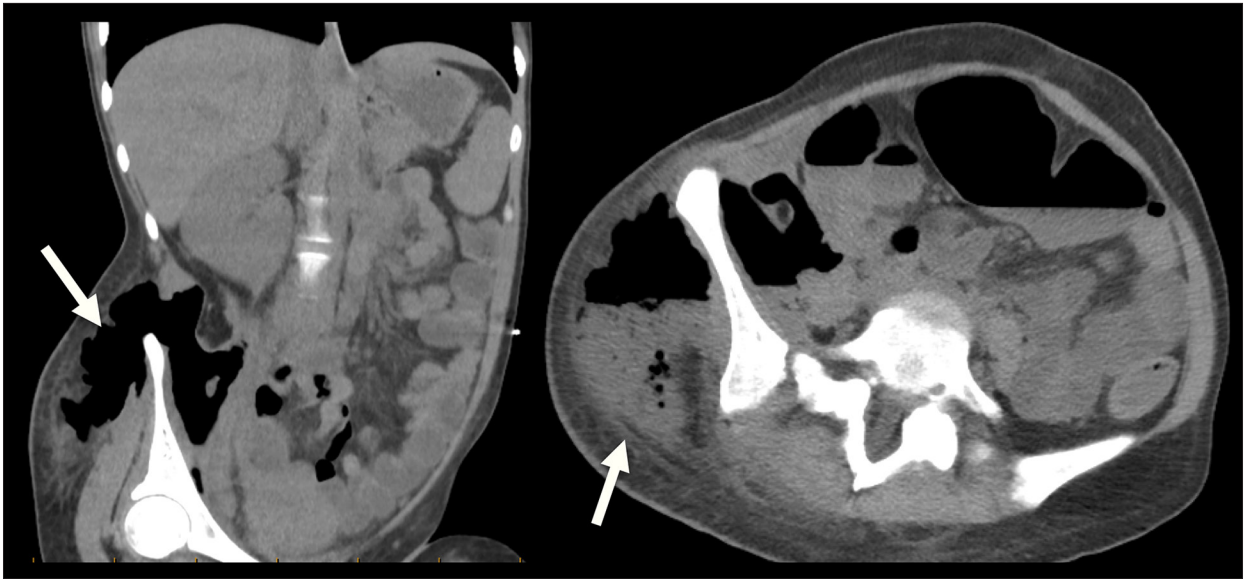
Preoperative CT scan of the abdomen and pelvis without IV and PO contrast reveals large complex air-fluid collection within the right flank, right retroperitoneum, and right lateral abdominal wall just superior to the right iliac crest (see arrows). Air extends through the right retroperitoneum infiltrating the iliopsoas space.
